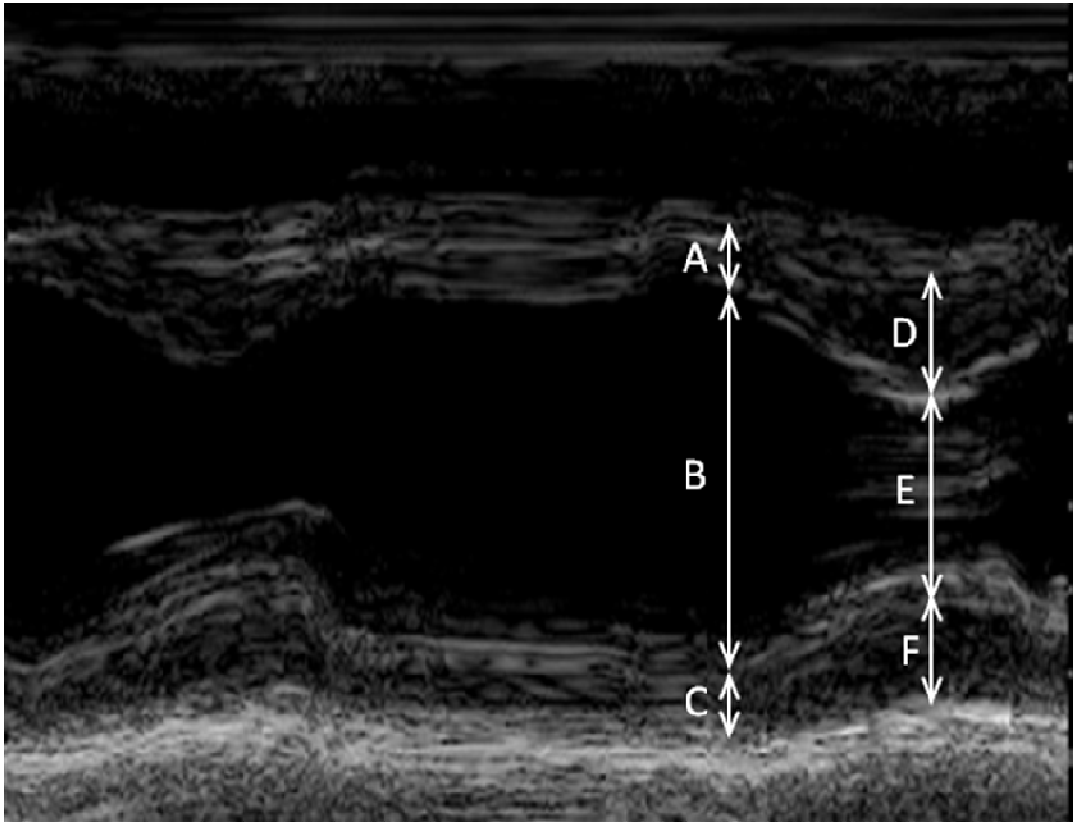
A two-dimensional guided M-mode echocardiographic image derived from a Hewlett Packard model 5500 utilised to assess left ventricular dimensions. A, septal wall thickness at end diastole; B, left ventricular end diastolic diameter; C, posterior wall thickness at end diastole; D, septal wall thickness at end systole; E, left ventricular end systolic diameter; F, posterior wall thickness at end systole.
